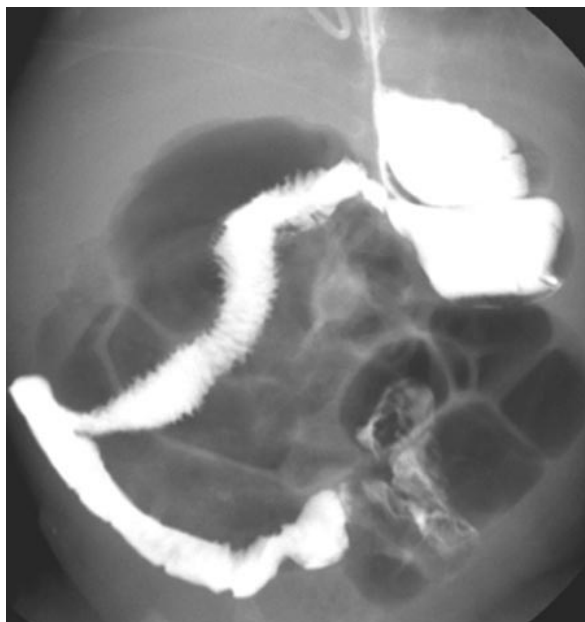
Radiograph obtained with barium in the upper GI tract of an infant with previously repaired gastroschisis and obligatory malrotation shows a markedly abnormal course of the duodenum and jejunum in the right abdomen.
